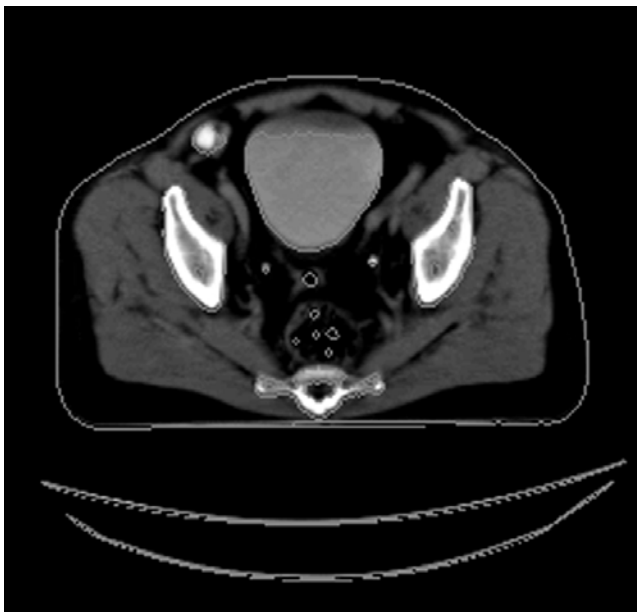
Image fusion using the technique of contour overlays of MRI data (outline of bony structures and bladder) onto registered CT images from a pelvis examination. The data sets were registered using a manual, interactive, rigid body technique.
